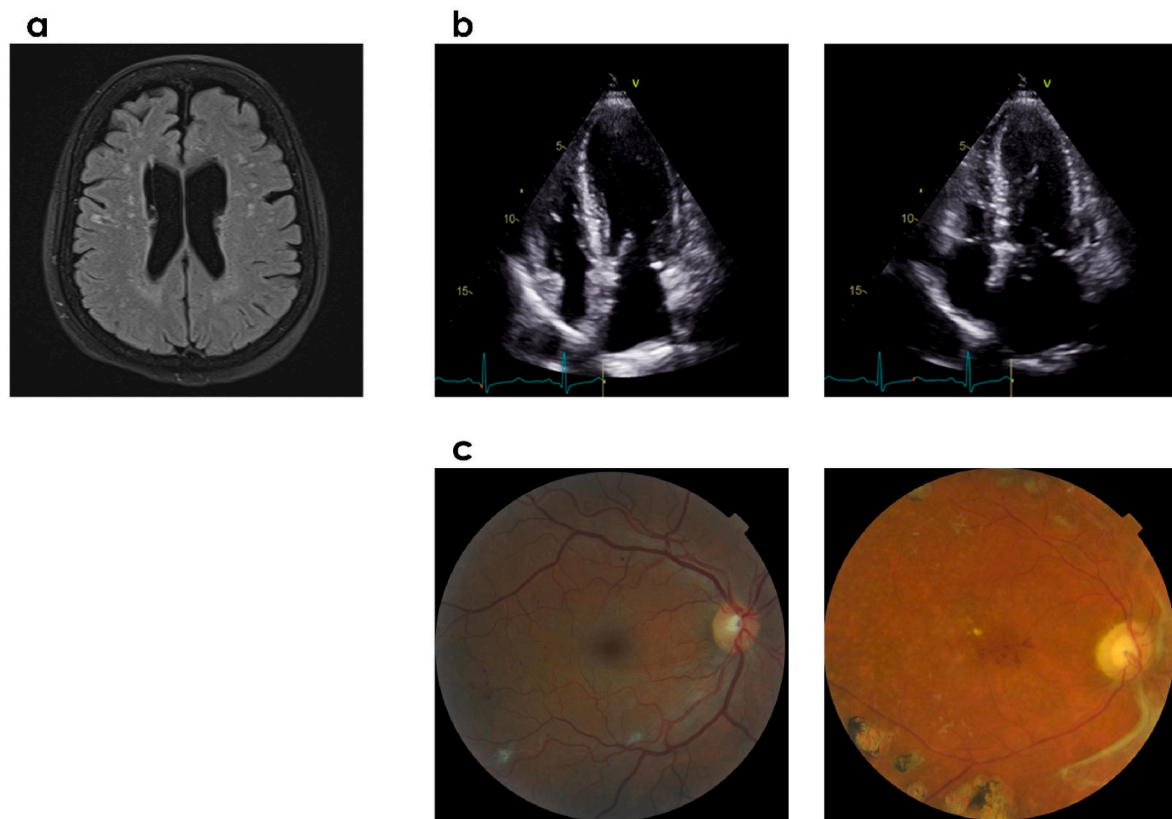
Sample hypertensive patient images captured through various imaging modalities. A) T2 Flair hyperintensities noted in a patient with HTN, b) Apical 4 chamber view at end-diastole and end-systole, and c) HTN fundus images.
